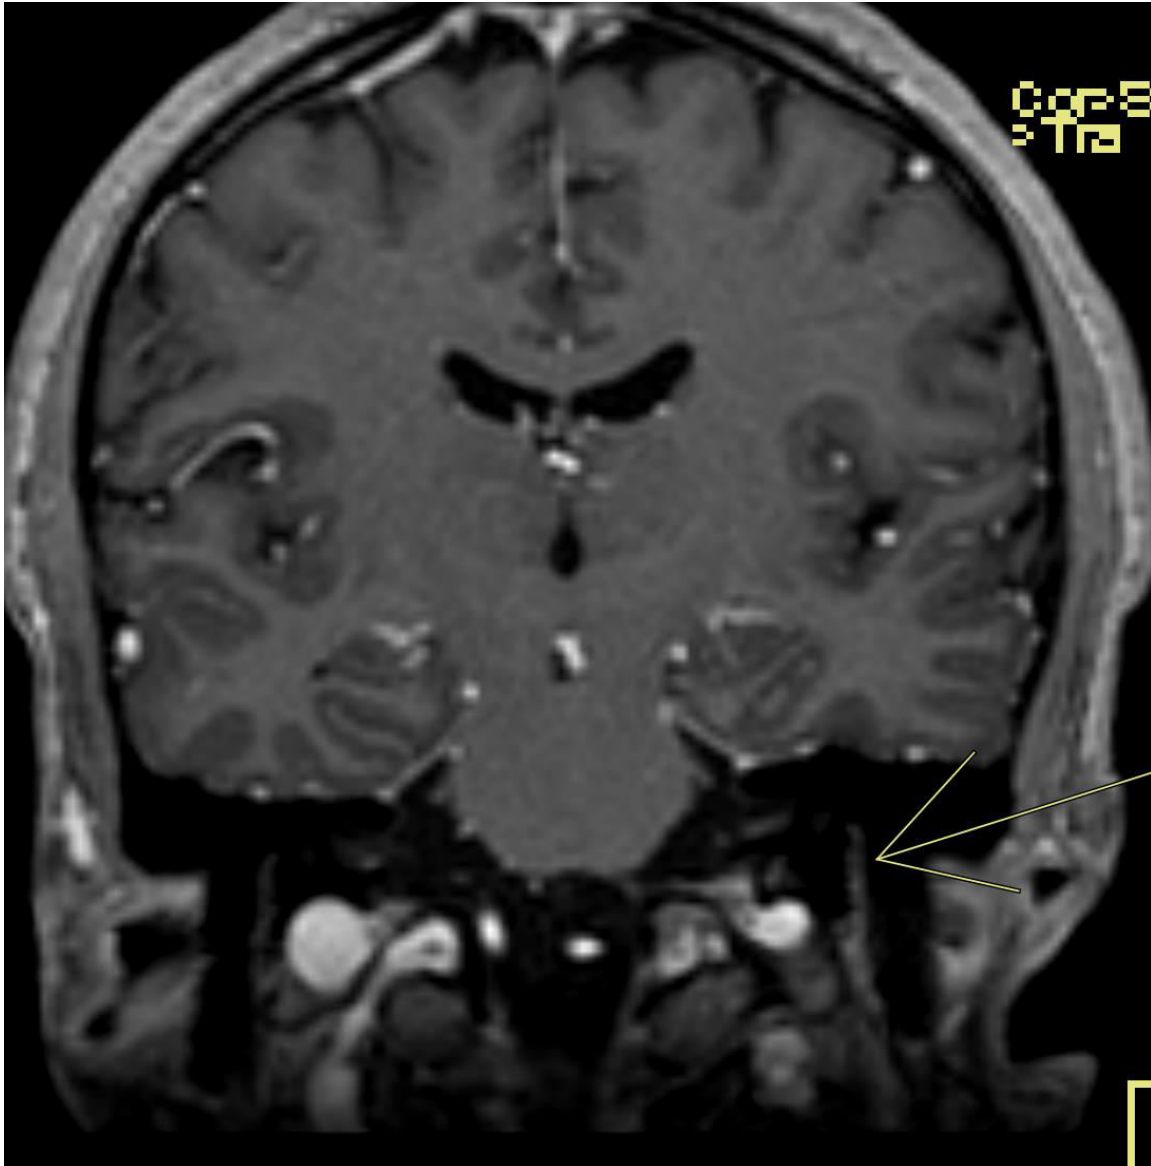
Follow-up brain MRI showed subtle left facial nerve smooth enhancement involving the labyrinthine, tympanic, and mastoid segments
